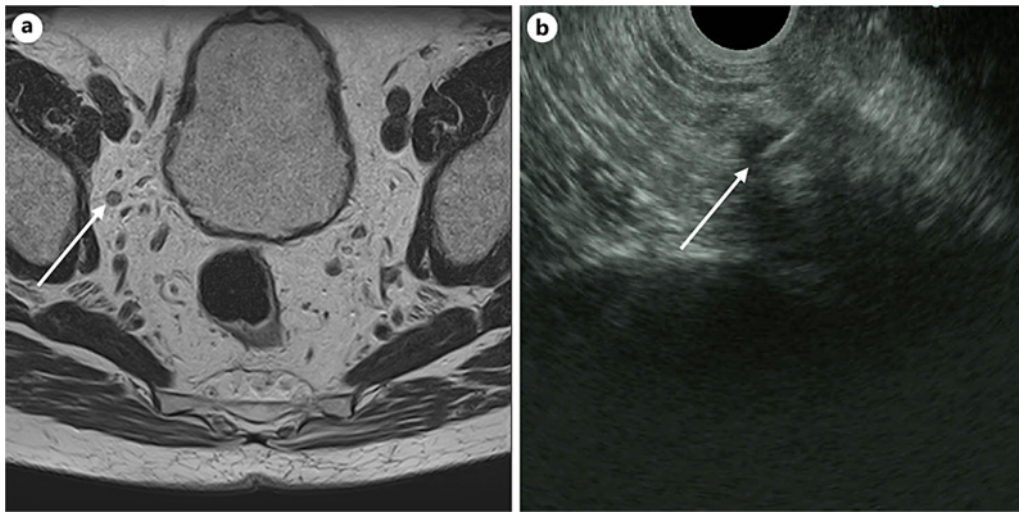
a, b MRI and EUS-FNA images of a suspected lymph node outside the perirectal fascia in the right obturator foramen.
